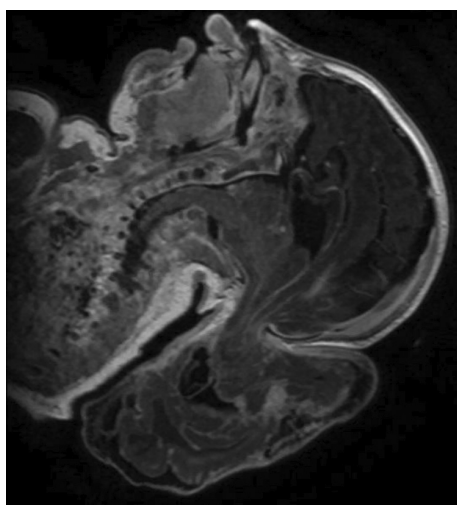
Magnetic resonance imaging revealed a 1.4 cm calvarial defect with a giant occipital encephalocele containing a large amount of dysplastic brain tissue.
